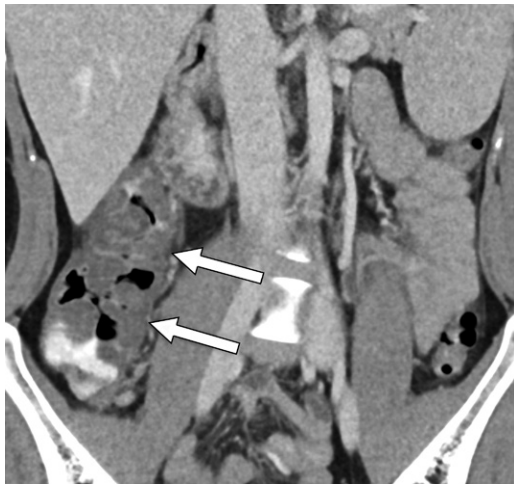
Hemorrhagic *Escherichia coli* colitis in a 49-year-old man who presented with abdominal cramps and blood in the stool. Coronal dual-energy mixed (blended) CT image shows marked cecal and ascending colonic wall thickening, with associated pericolic fat stranding (arrows). High-attenuation intraluminal fluid in the colon was likely ingested material, given its presence on virtual noncontrast images (not shown). Clinically, the patient was found to have hemorrhagic *E coli* colitis.
